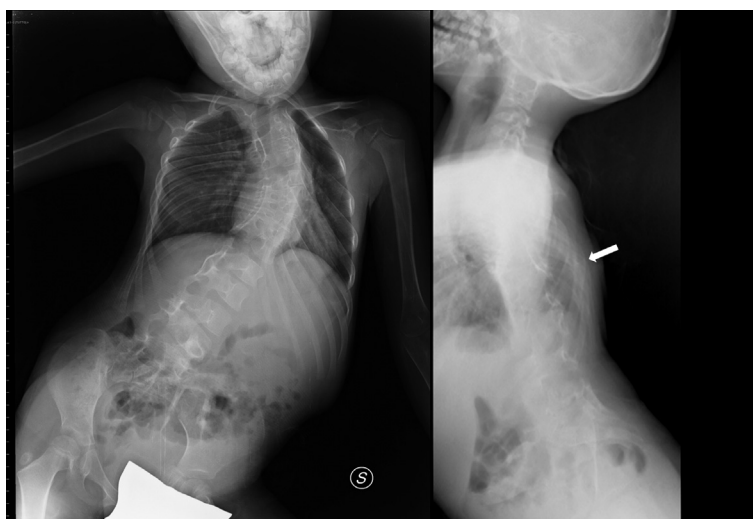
Conventional radiograph of the spine (posterior-anterior and lateral view) showing scoliosis with rib hump (white arrow).
